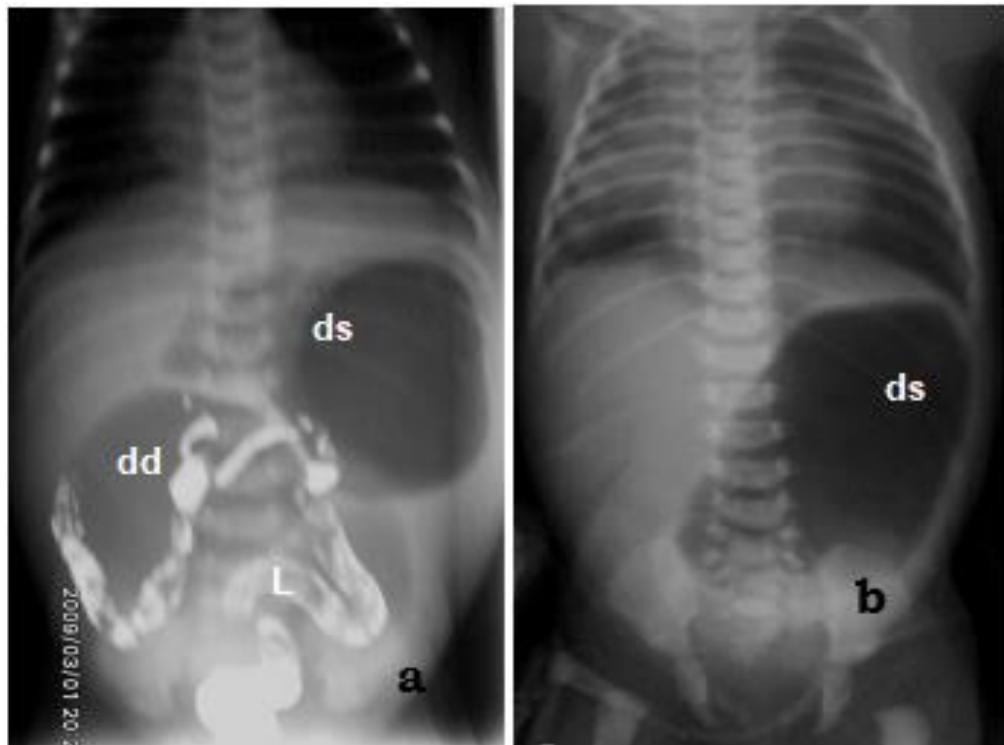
a. Barium enema in a neonate with jejunal stenosis and microcolon. Note the gas-filled dilated stomach (ds) on the left hypochondrium and the gas-filled dilated duodenum (dd) giving the double *bubble sign*. The large colon (L) is small in calibre. b. Plain radiograph of duodenal atresia in a day old baby. Note the single large gas-filled dilated stomach (ds) giving the single *bubble sign*. Also, note the consolidation of the right upper lobe due to aspiration pneumonia.
